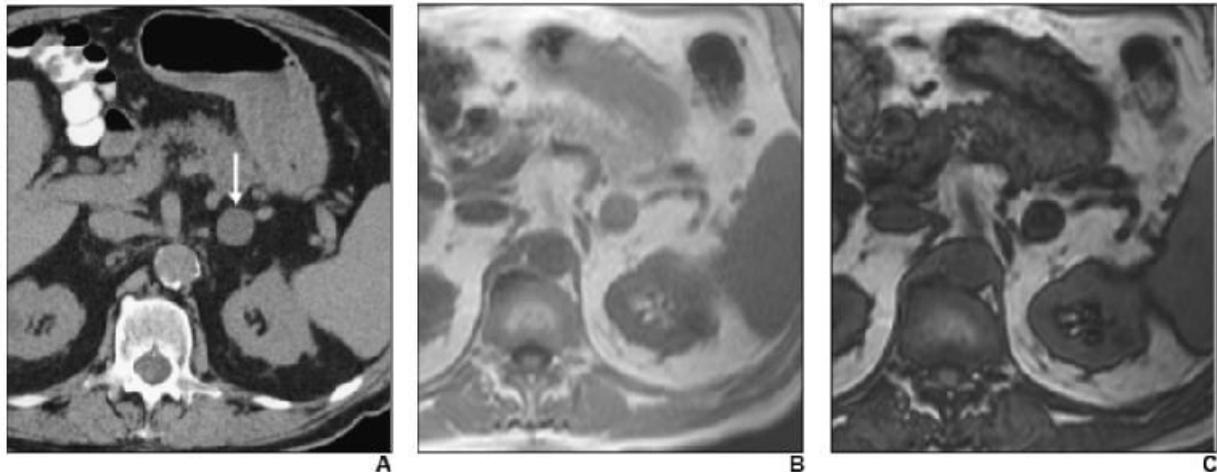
84-year-old man with adrenal adenoma that was characterized using chemical shift MRI but not with unenhanced CT.
